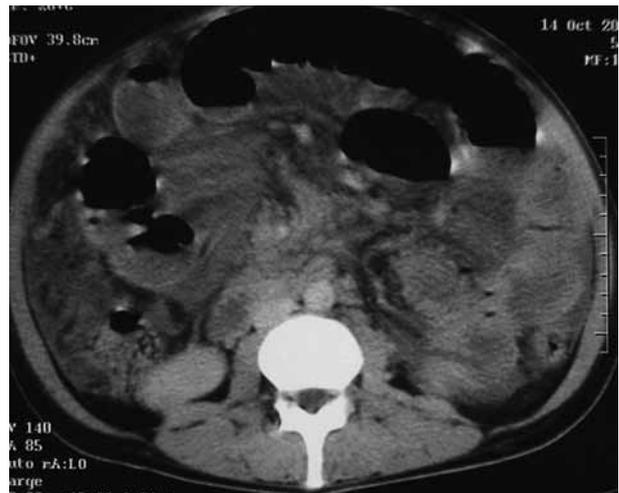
Contrast enhanced CT scan shows diffuse free liquid and thickness on the bowel wall.
